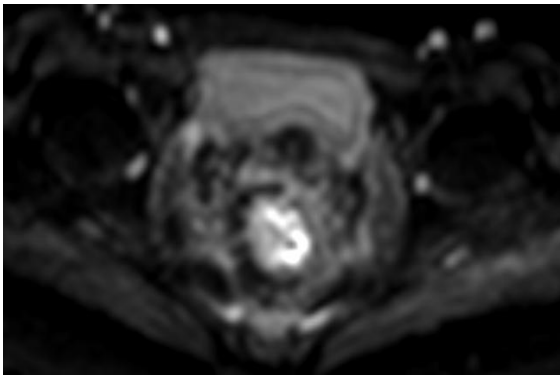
Corresponding DWI images at the site of tumour
